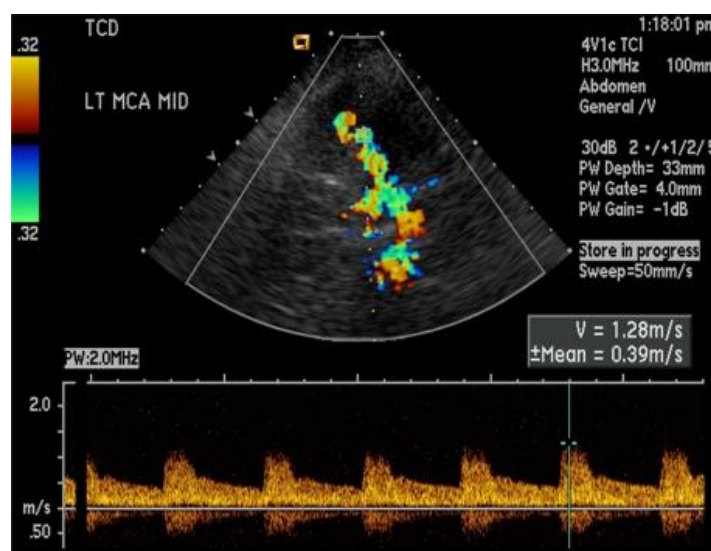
Transcranial Doppler in healthy patient's Middle Cerebral Artery (Birenbaum D et al. 2011)
